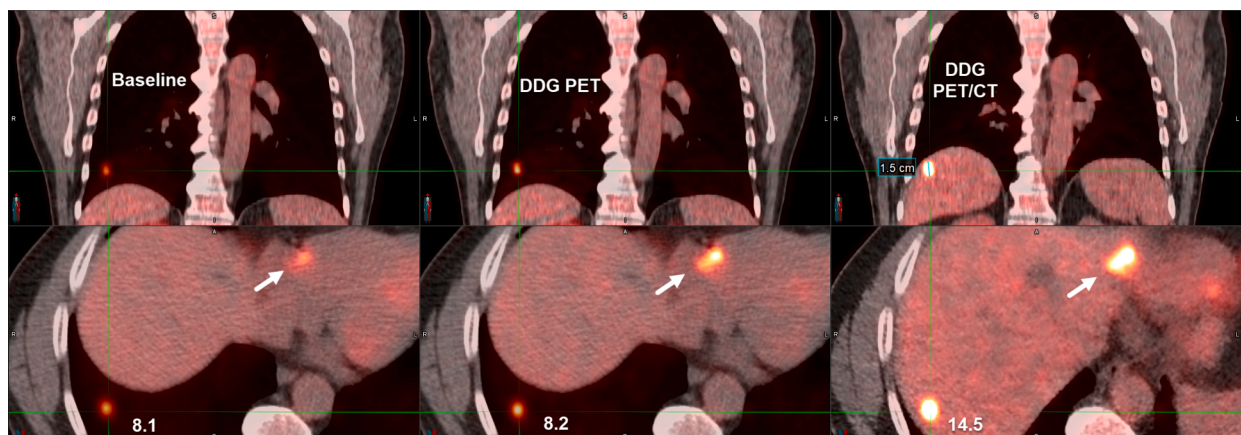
From left to right are the baseline WB PET/CT, DDG PET (attenuation correction by WB CT in the baseline WB PET/CT), and DDG PET/CT (DDG PET attenuation correction by DDG CT) of an ^{18}F -FDG study. The top and bottom rows are coronal and axial fusions of the PET and CT images. A liver lesion of 1.5 cm at the cross-hair in DDG PET/CT was mispositioned to the lungs in the baseline WB PET and DDG PET. The SUV_{max} of the liver lesion was 8.1, 8.2, and 14.5 for the baseline WB PET/CT, DDG PET, and DDG PET/CT, respectively. The liver lesion by an arrow in DDG PET/CT was also mispositioned to the heart in the baseline WB PET/CT and DDG PET.
